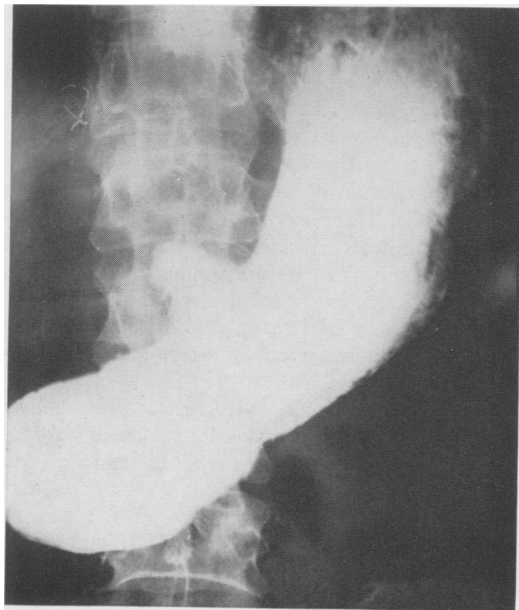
X-ray of O. W. B. taken January 23, 1953. There is marked retention and a huge gastric ulcer.
